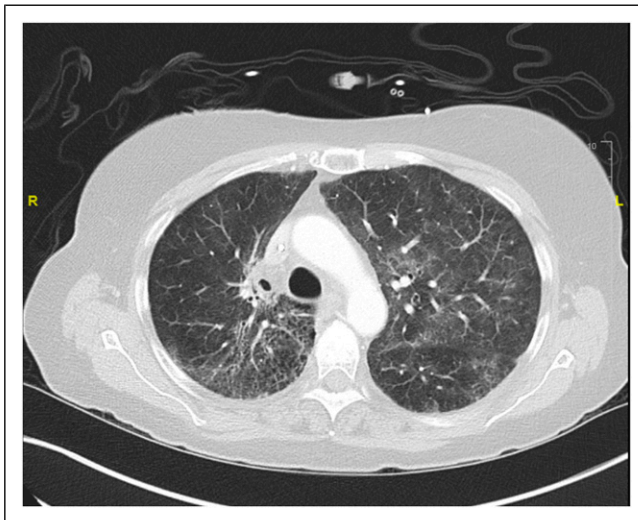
Computed tomography of the thorax demonstrating pulmonary nodules with multifocal ground-glass opacification suggestive of nonspecific pneumonia in patient 1.
